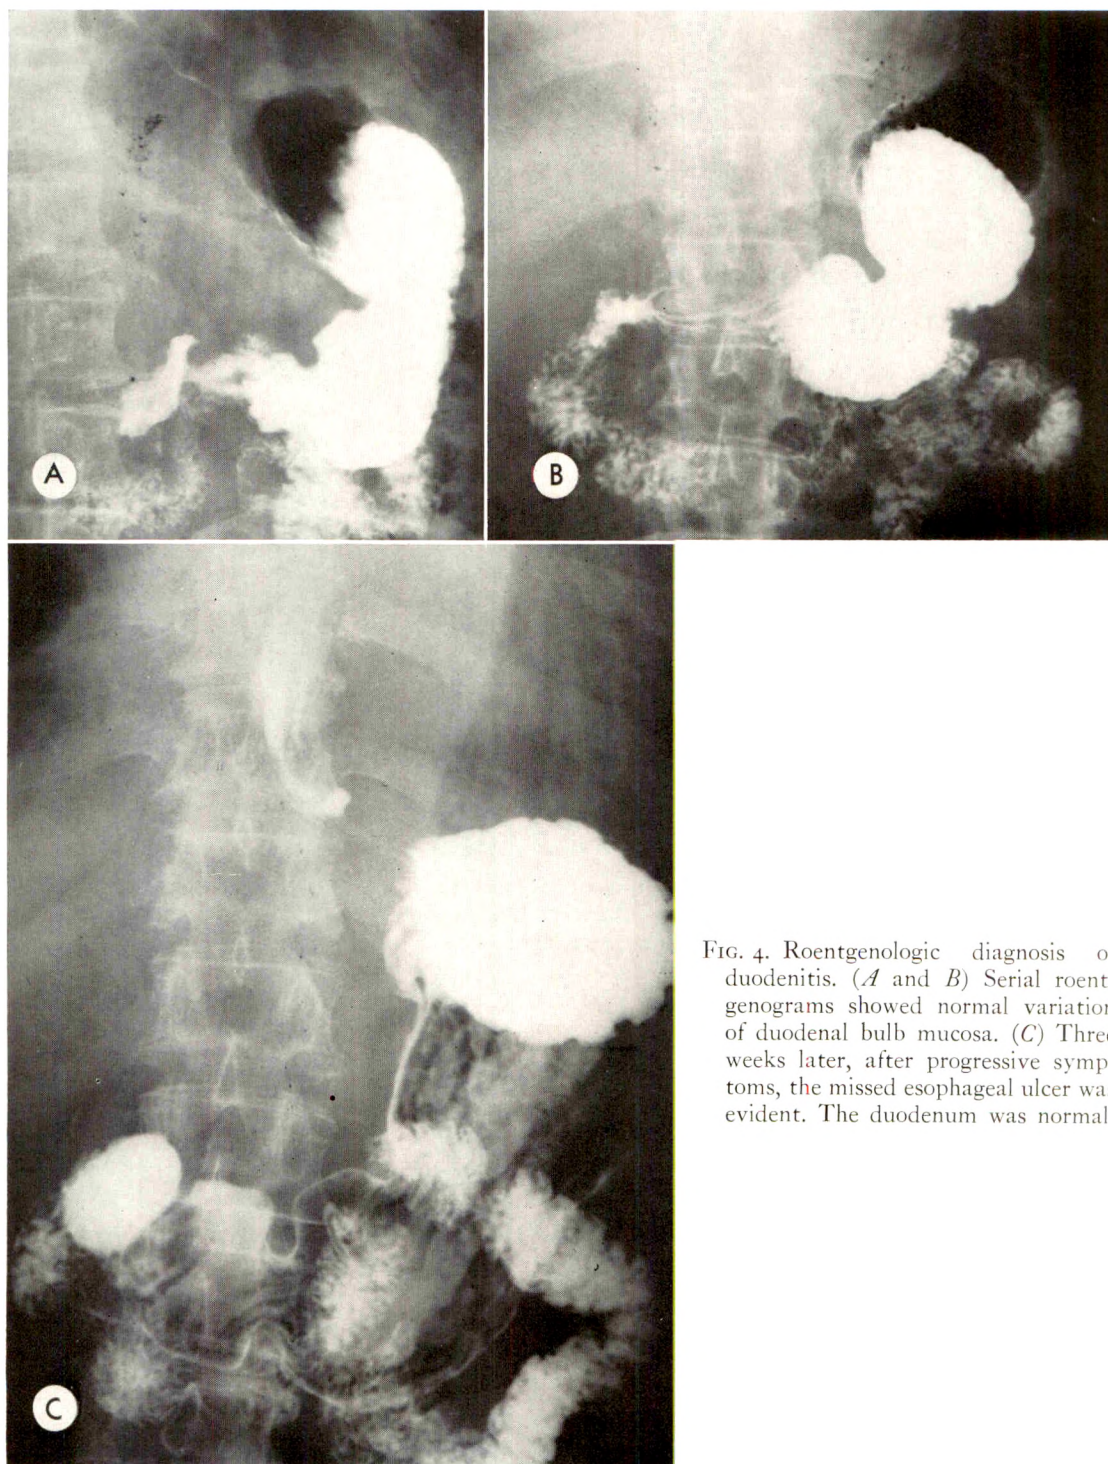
Roentgenologic diagnosis of duodenitis. (A and B) Serial roentgenograms showed normal variation of duodenal bulb mucosa. (C) Three weeks later, after progressive symptoms, the missed esophageal ulcer was evident. The duodenum was normal.
